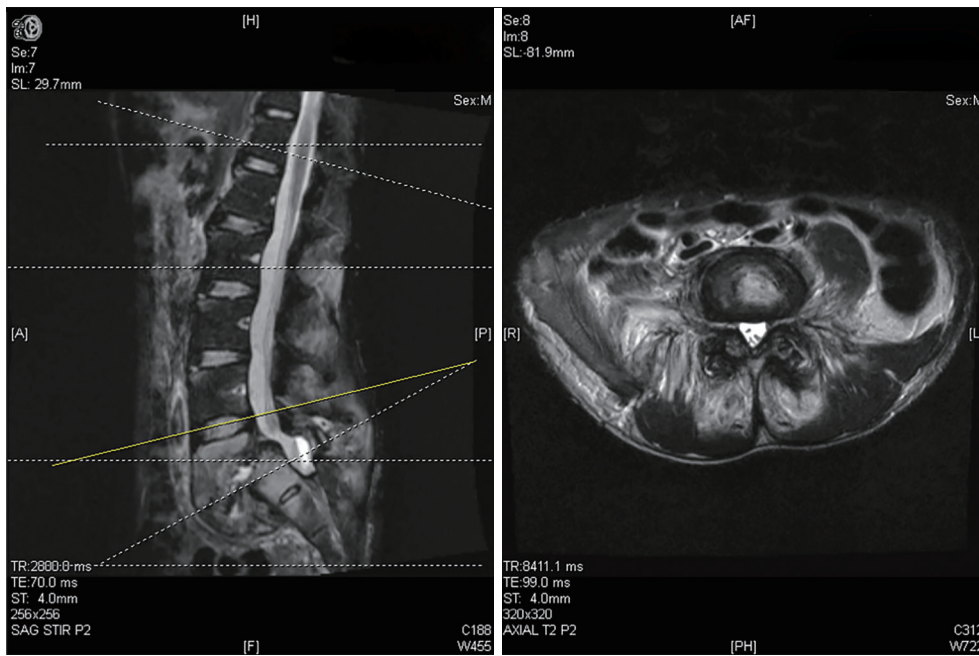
T2-weighted MRI imaging of lumbar spine (L4-5) on presentation. MRI, magnetic resonance imaging; TR, repetition time; TE, echo time.
